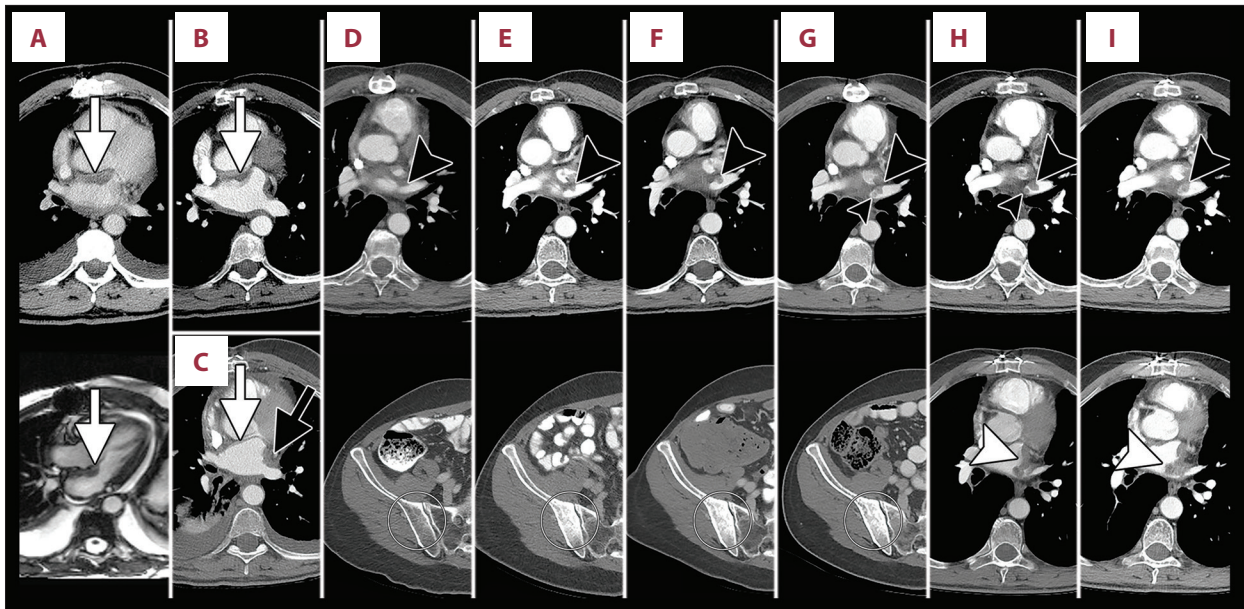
Time course of local and metastatic disease. (A) Post-operative baseline contrast-enhanced CT chest (upper panel) and cardiac MRI (bottom panel, white-blood image) in December 2015 (no pre-operative CT or MRI was performed, and echocardiograph images were not available). White arrow indicates residual disease along the anterior wall of the left atrium. (B) CT chest from April 2016 after 6 cycles of AI shows continued improvement at the anterior wall of the left atrium (white arrow). (C) CT chest from July 2016 showed resolution of the anterior wall disease (white arrow) and post-operative scarring at the left lateral wall (black arrow). (D) Contrast-enhanced CT from October 2016 was negative. Black arrowhead points to site of future disease in the left superior pulmonary vein (upper panel), and white circle indicates area of future bone metastasis (bottom panel). (E) CT from September 2017 shows new nodularity in the left superior pulmonary vein (black arrowhead, upper panel) and new blastic bone metastasis in the right posterior ilium (white circle). (F) CT from December 2017 shows stable disease on AI. (G) CT from May 2018 showed a new nodule in the left superior pulmonary vein (small black arrowhead) and no appreciable change in the right posterior iliac lesion (white circle). (H) CT from June 2018 showed further enlargement of the superior pulmonary vein lesions (small and large black arrowheads, upper panel) and new disease along the lateral wall of the left atrium (white arrowhead, bottom panel). (I) CT from September 2018 showed unchanged disease in the left superior pulmonary vein (black arrowhead, upper panel) and progressive disease along the lateral wall (white arrowhead, bottom panel). CT – computed tomography, MRI – magnetic resonance imaging; AI – adriamycin and ifosfamide.
